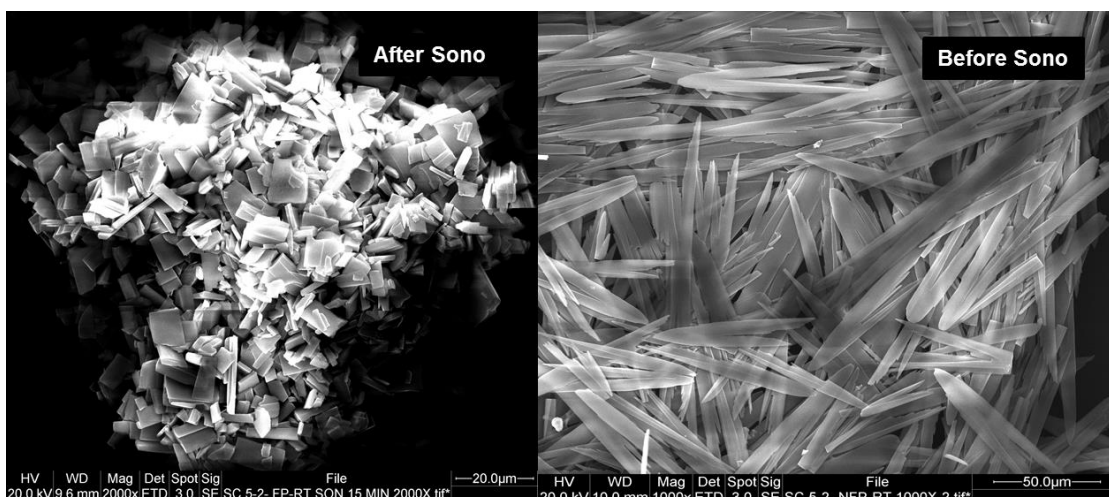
SEM images of curcumin particles which precipitated from ethanol and water without ultrasound. *Before-sono is the curcumin particles prepared without ultrasound, *After-sono is the formed particles sonicated for 15 minutes.
